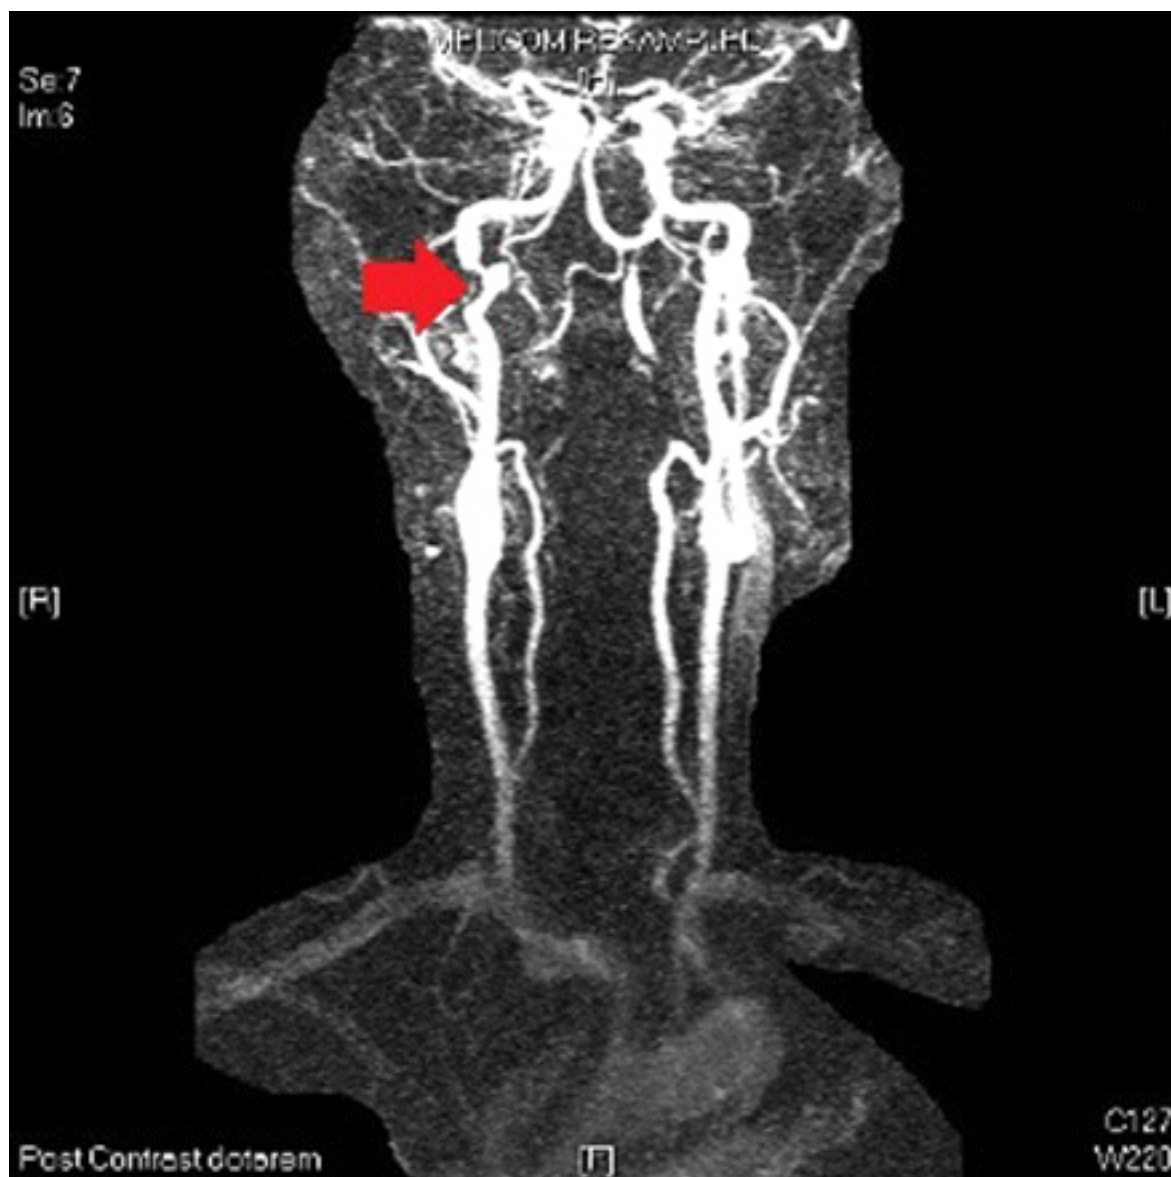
MRI of carotid artery. The arrow shows narrowing of the lumen of the carotid artery caused by intramural haematoma
